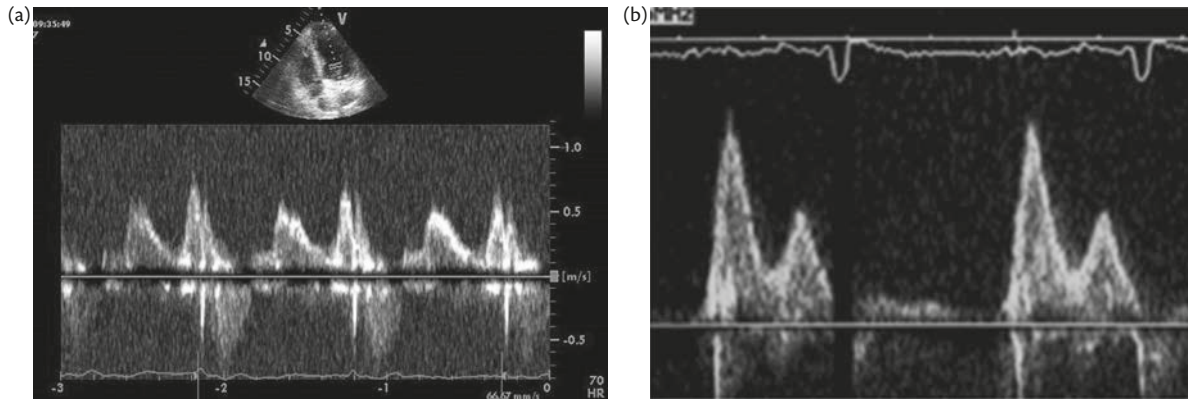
Mitral flow recorded using pulsed wave Doppler. (a) Diastolic dysfunction grade 1. (b) Grade 3.
